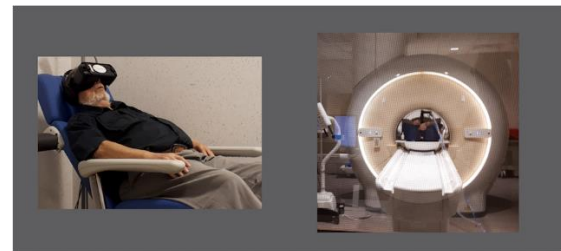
The Oncomfort® device was used for a hypnotising Virtual Reality Animation (VRA) with the aim to decrease the patient anxiety level before that he underwent a MRI acquisition session with Mechanically-assisted and non-invasive ventilation (MANIV).
